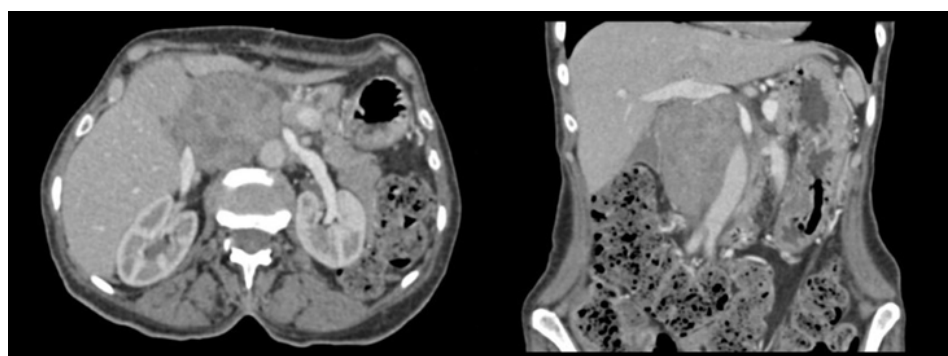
Abdominal enhanced CT in axial and coronal plan, demonstrating a large and heterogeneous mass encasing the inferior vena cava, with masse effect on the adjacent aorta.
